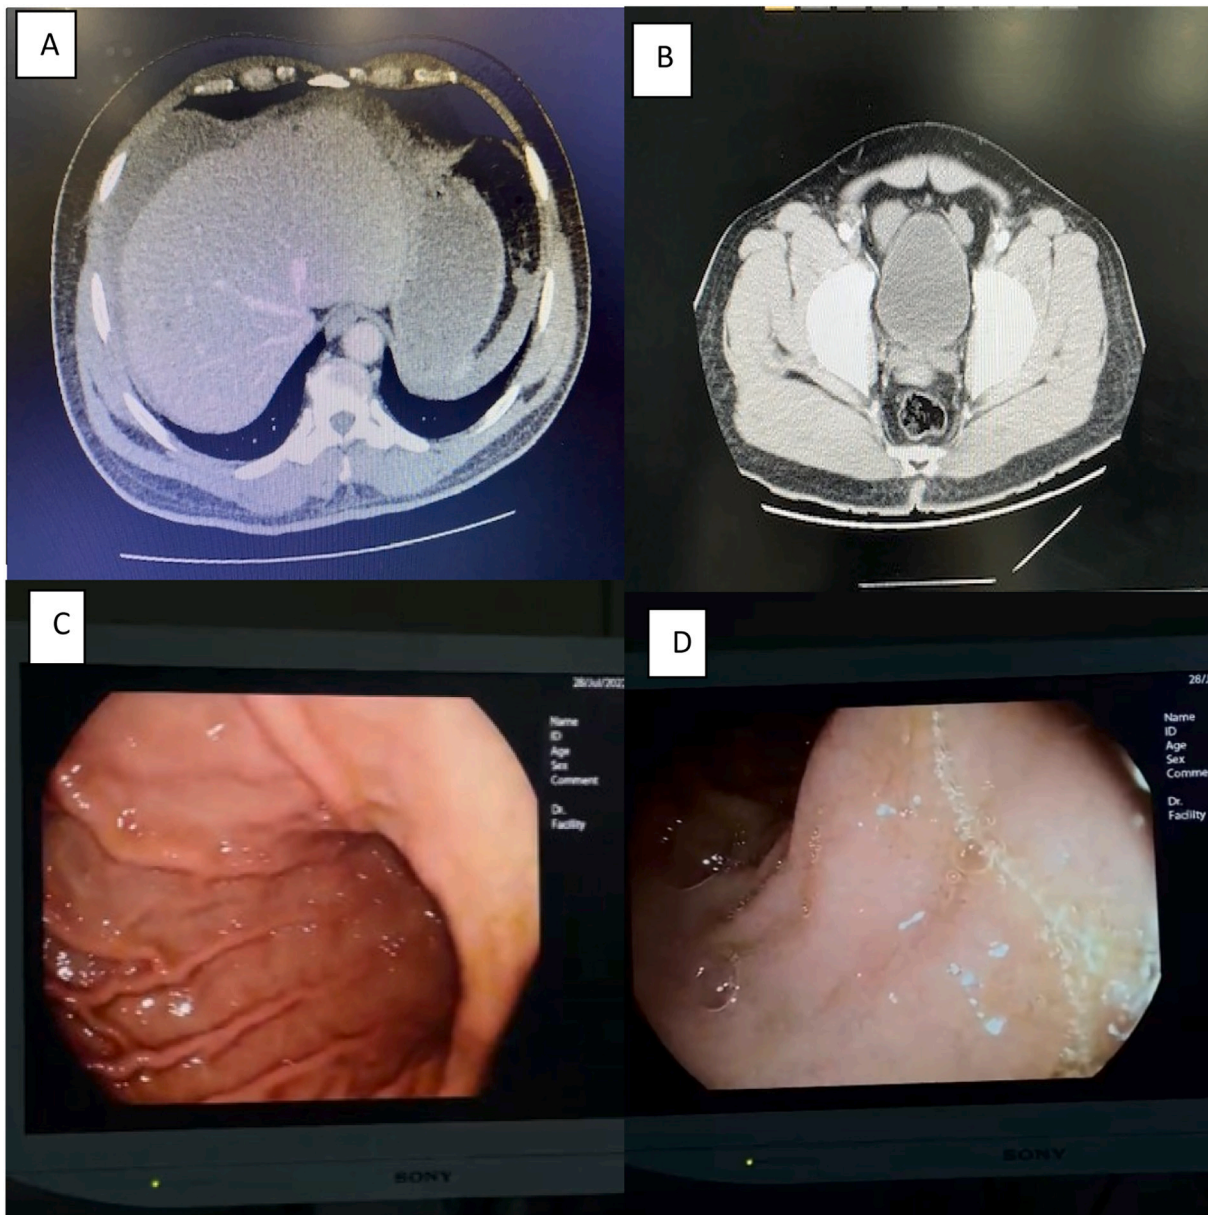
Enhanced abdominal CT revealed subcapsular liver and splenic hematoma (A) urinary bladder hematoma (B) upper endoscopy demonstrated no bleeding from stomach and duodenum (C, D).
